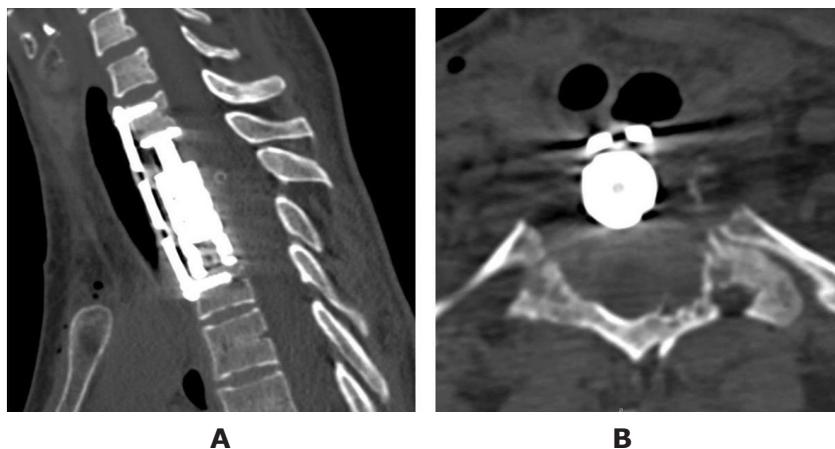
Spiral computed tomography of the cervical-thoracic junction after the first stage of surgery: A – sagittal reconstruction; B – section at the level of the Th2 vertebra
